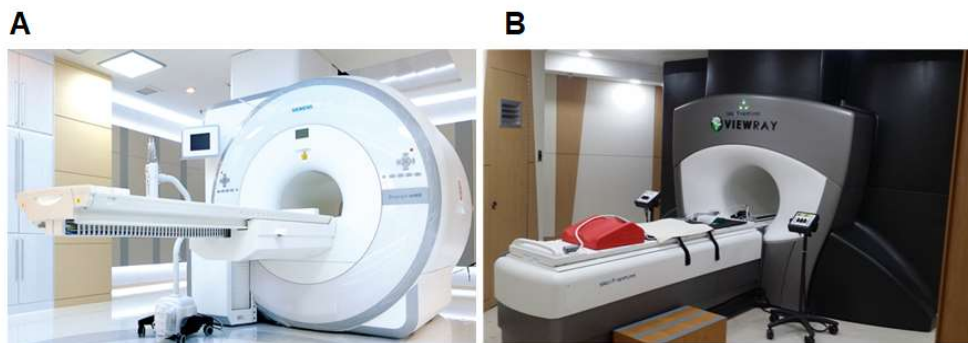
MR-integrated medical system. (A) PET/MRI : Siemens Biograph mMR
